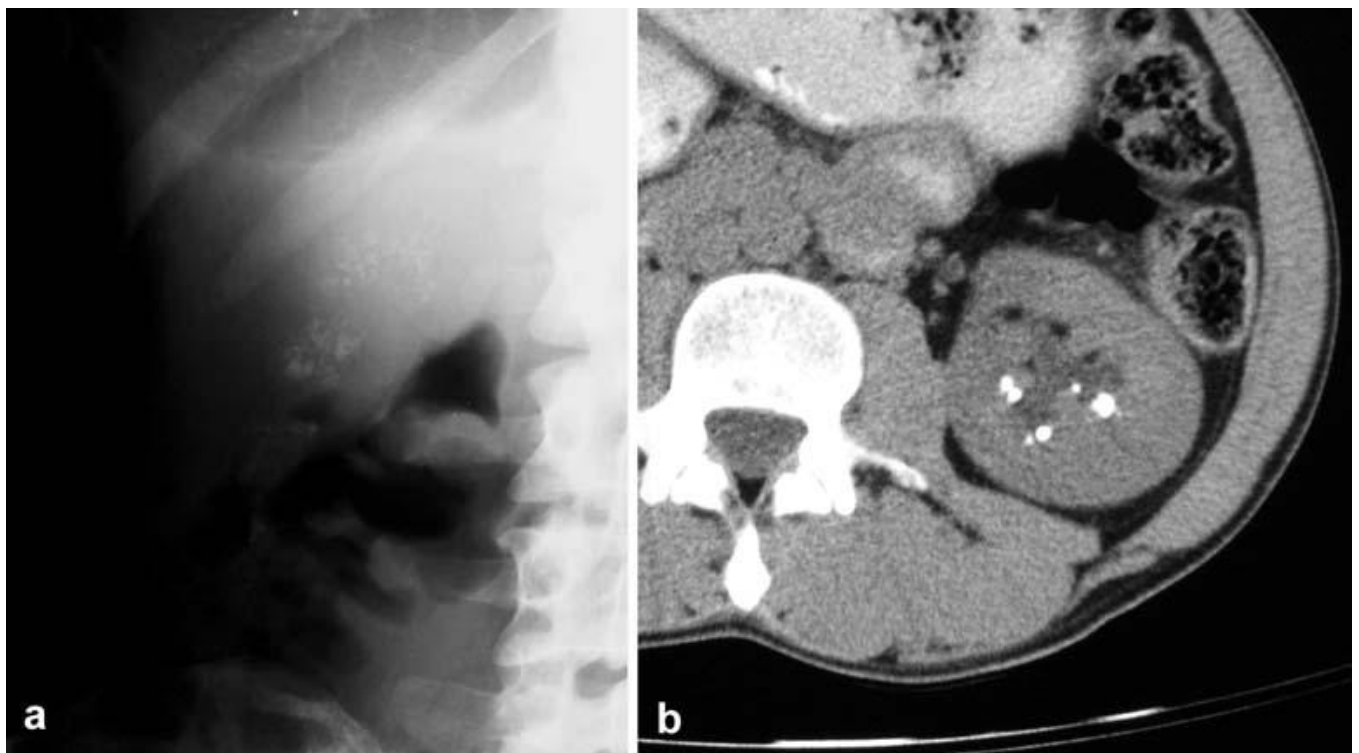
Nephrocalcinosis in medullary sponge kidneys KUB and CT (different patient (*Quoted from Rao, 2004*)).
